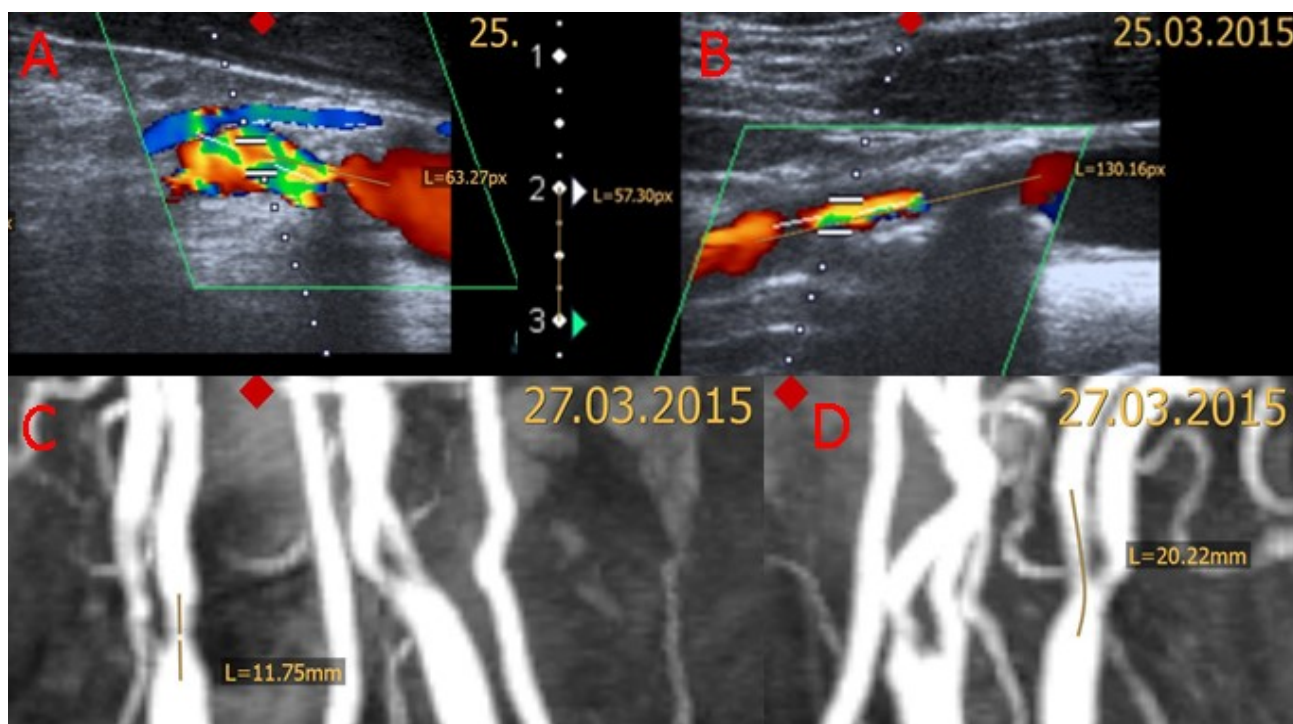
Ultrasound examination (patient 95) showing an ICAD of 60% with a length of 11 mm and an echogenic plaque on the asymptomatic right side (A); on the contralateral side, an ICAD of 70% with a length of 23 mm and an echogenic plaque was detected, which caused the ischemic infarction (B), MRA showing a 12 mm long ICAD on the asymptomatic right side (C) and a 20 mm long ICAD on the symptomatic left side (D)
